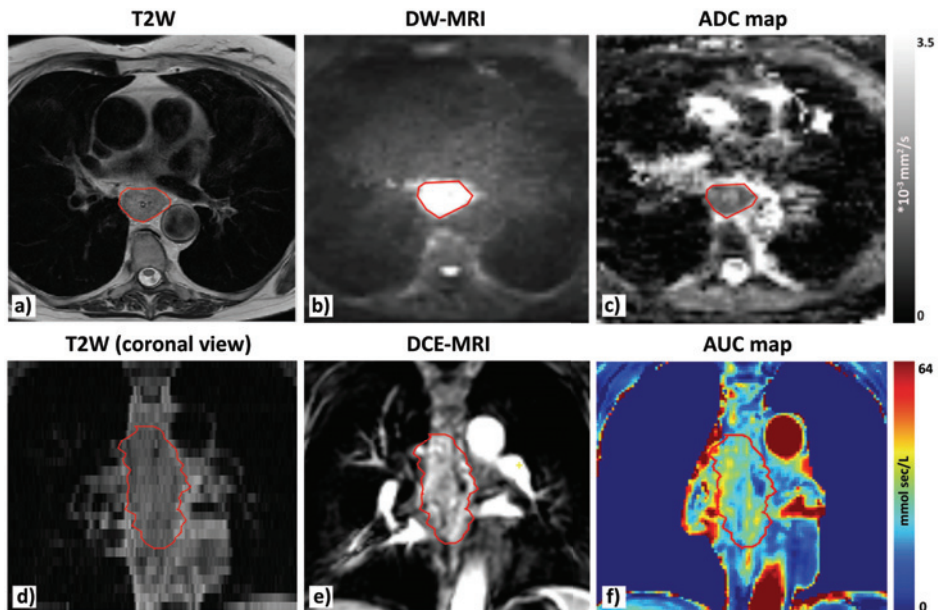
An example of acquired MRI scans for one patient for one time point (pre scan). In (a) a T₂W scan is shown with in (d) the coronal view of the same scan. (b) A b800 DW-MRI scan and its corresponding ADC-map in (c). In (e) the 24th scan of a DCE-MRI series is shown, during inflow of contrast in the tumor. Corresponding calculated AUC-map is found in (f).
